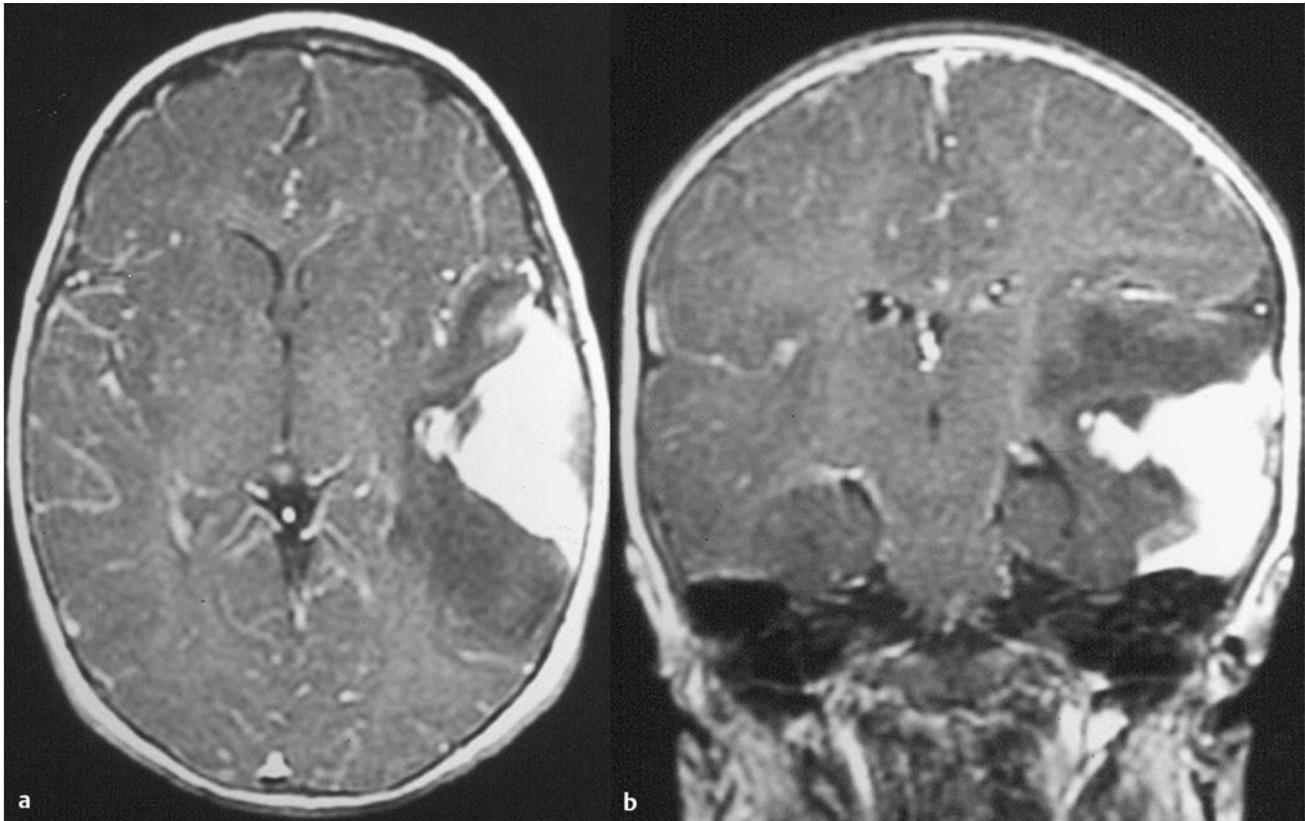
Desmoplastic infantile ganglioglioma. (a) Axial and (b) coronal magnetic resonance images of a 5-month-old boy who presented with seizures. A supratentorial location, superficial or cortical origin, and very large size are all characteristic features manifested in this desmoplastic infantile ganglioglioma.
